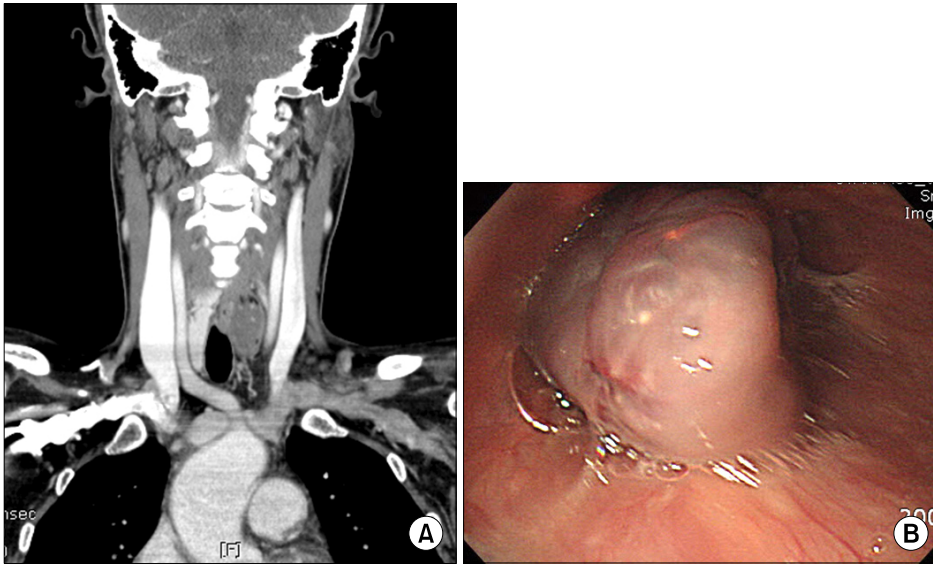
(A) Neck and chest CT. 3.6 cm oval mass with slightly low attenuation in the upper esophagus and a 7 mm nodule in the left lobe of the thyroid gland. (B) Esophagogastroscopy. 3.5 cm smooth, soft, dark purple, mobile mass, which was located just beneath the upper esophageal sphincter.
